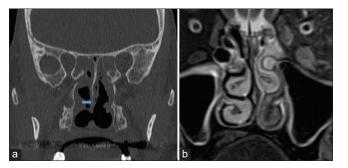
(a) Coronal CT image shows mucosal thickening along the ethmoid sinuses and nasal cavity with nasal septal perforation/ erosion (blue arrow). (b) A black turbinate sign shows a lack of normal enhancement of turbinate due to necrosis on the post-contrast T1W image
